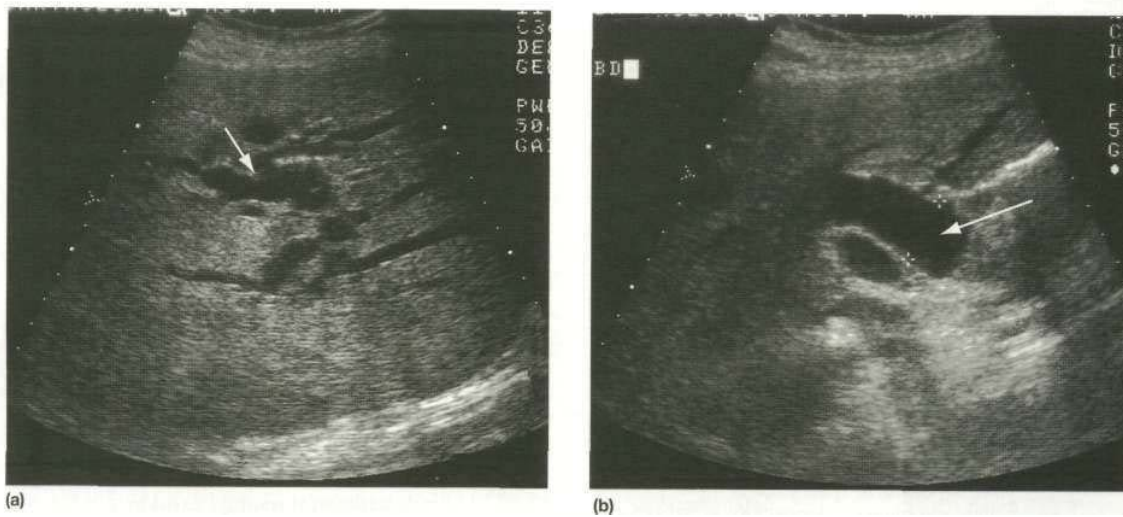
Liver ultrasound showing (a) dilated intrahepatic bile ducts (arrow), (b) common bile duct (arrow). The normal bile duct measures 6 mm at the porta hepatis.
